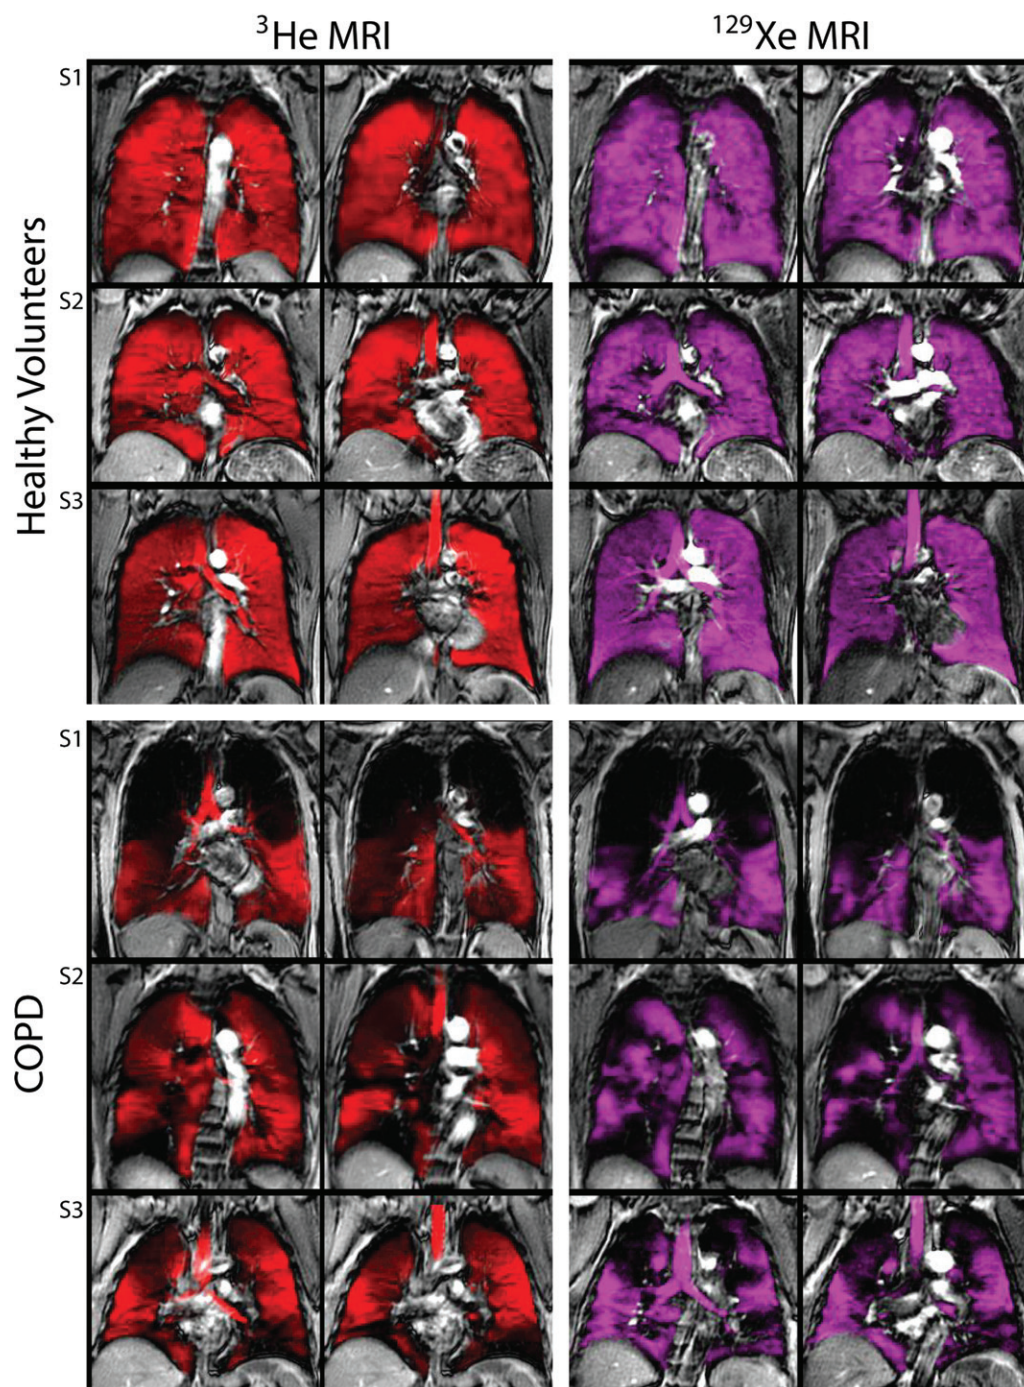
Static ventilation ^3He and ^{129}Xe MR images in three healthy volunteers and three patients with COPD. Images of the two coronal center sections, where trachea and two main bronchi are clearly visible, are registered to grayscale ^1H MR images of thorax. Volunteer in S1 is 75-year-old woman with percentage predicted FEV_1 of 93% and FEV_1/FVC of 70%; volunteer in S2 is 57-year-old man with percentage predicted FEV_1 of 95% and FEV_1/FVC of 72%; volunteer in S3 is 51-year-old man with percentage predicted FEV_1 of 120% and FEV_1/FVC of 83%. Patient in S1 is 77-year-old woman with percentage predicted FEV_1 of 50% and FEV_1/FVC of 20%; patient in S2 is 68-year-old woman with percentage predicted FEV_1 of 59% and FEV_1/FVC of 53%; patient in S3 is 71-year-old man with percentage predicted FEV_1 of 107% and FEV_1/FVC of 58%. ^3He gas distribution is displayed in red and ^{129}Xe gas distribution is displayed in purple.
